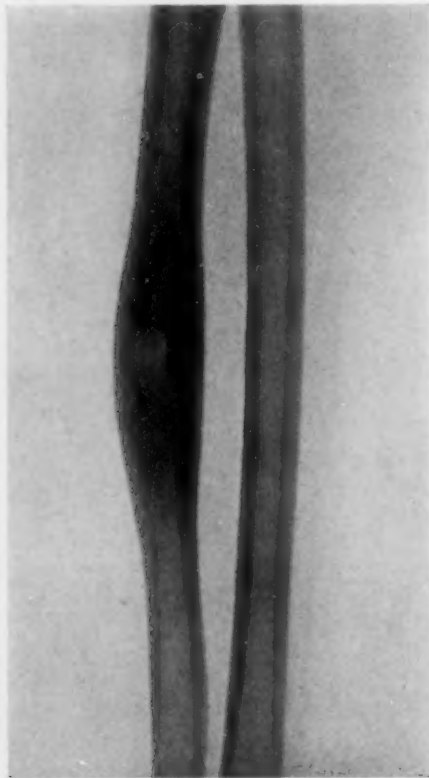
An X-ray photograph of an osteomyelitis of the ulna before operation. The roentgenographic characteristics are those of a thrombophlebitic lesion in a subsidiary branch of the nutrient artery, fixation point being in medulla of the bone. Small size of lesion indicates that actual vessel blocked is unimportant in the general vascular network of bone and that collateral circulation is abundant. Note that lesion does not extend across entire thickness of shaft and is fairly well localized. Entire focus was excised going into healthy tissue on all sides. Wound was packed wide open. On tenth day packing was removed and edges of wound were strapped together. Agglutination of wound surfaces followed.
